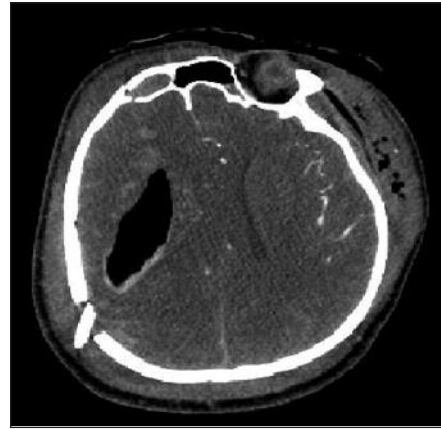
Computed tomography angiography of the patient showing no blood stream in the distal middle cerebral artery because of compression of the foreign body.
